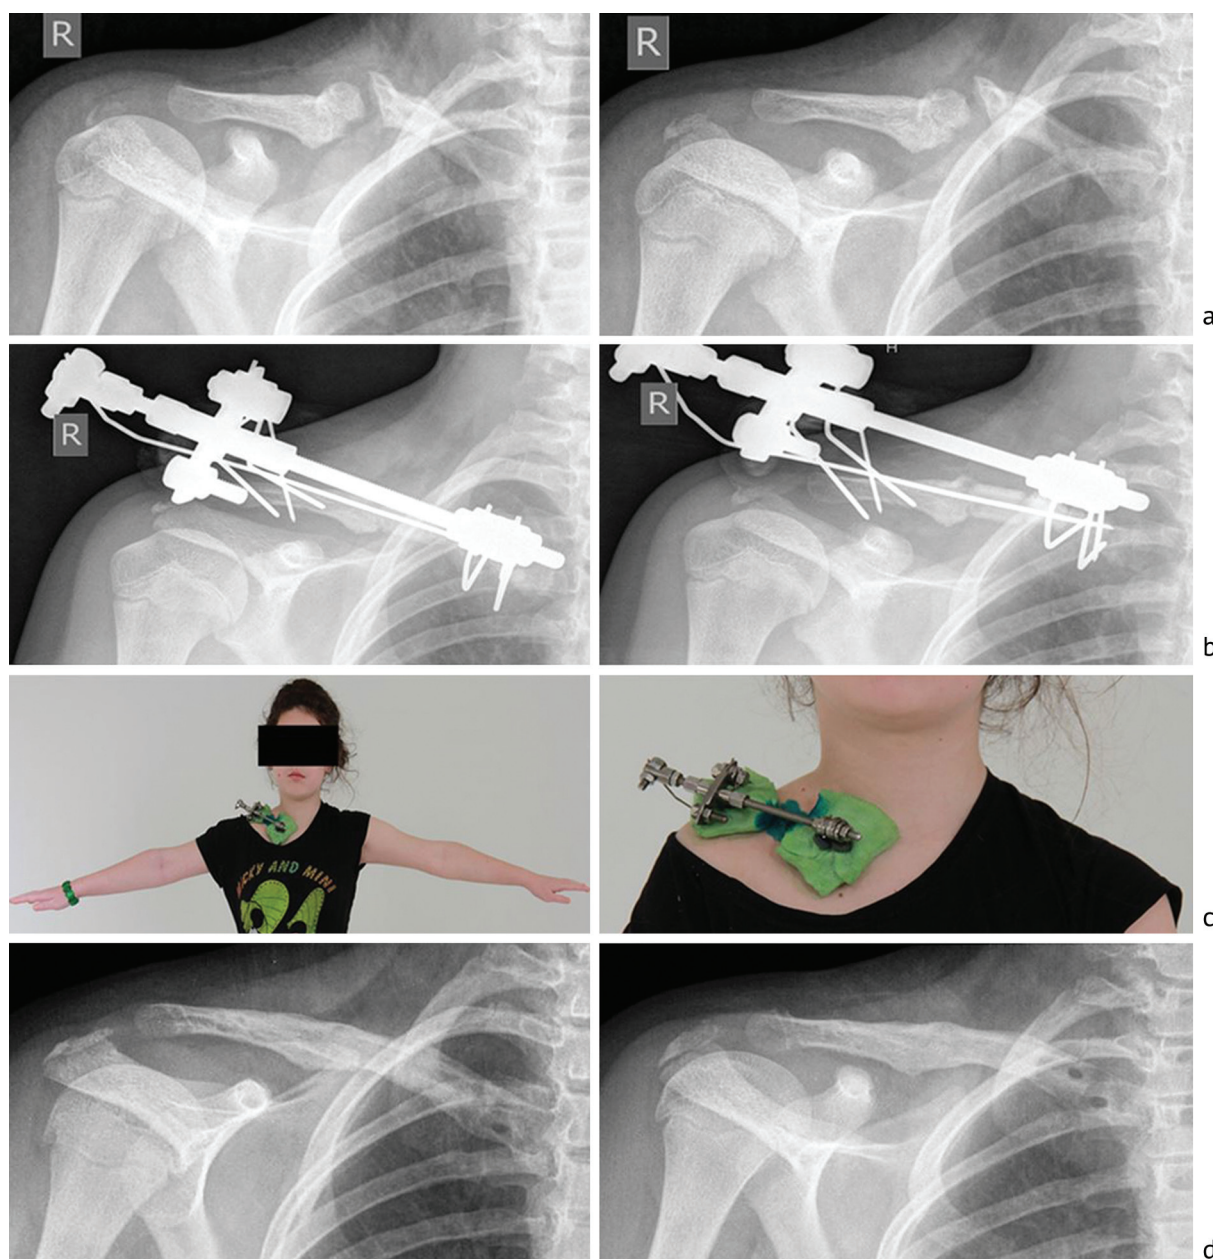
X-rays and photo of P1 (Table 1) with hypotrophic nonunion of the clavicle with a 5-mm gap and incongruent sclerotic ends of the fragments (a); defect repair and deformity correction upon mini-fixator placement and tight contact of the graft with the fragments (b); photo of the patient showing the shoulder function which is slightly restricted due to the placed mini-fixator (c); union and graft remodeling after 1-year (d)
